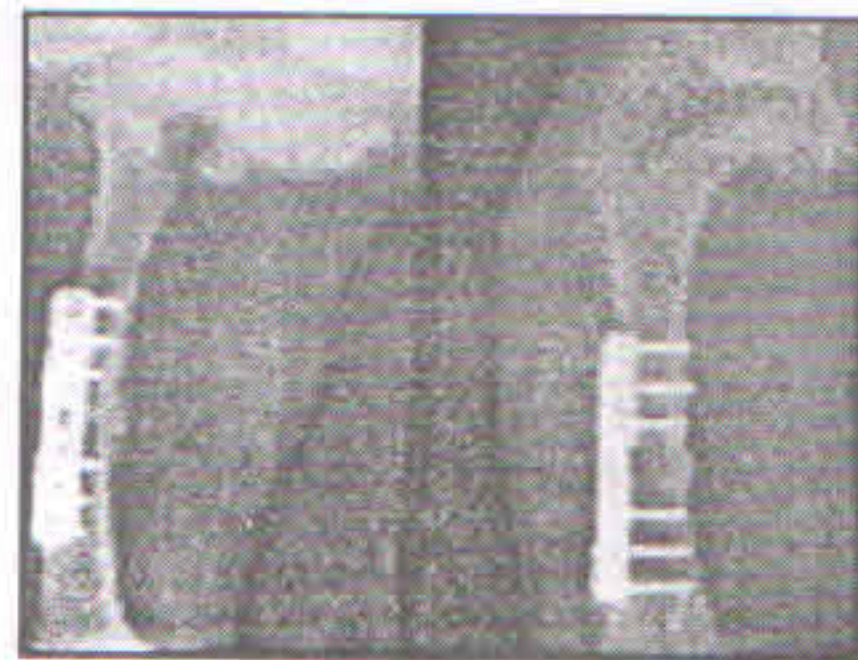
Followup x-ray of 6 months
